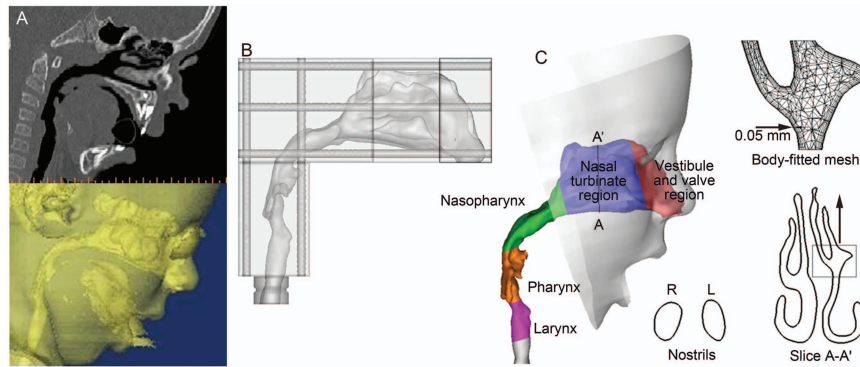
Nasal-laryngeal airway model development. A: 3-dimensional rendering of computed tomography images of a 5-year-old male for (B) in vitro measurement and (C) numerical analysis. The airway was divided into regions: nasal vestibule and valve region, nasal turbinate, nasopharynx, pharynx, and larynx. The computational mesh is composed of approximately 1.8 million unstructured tetrahedral elements and a fine near-wall pentahedral grid.
